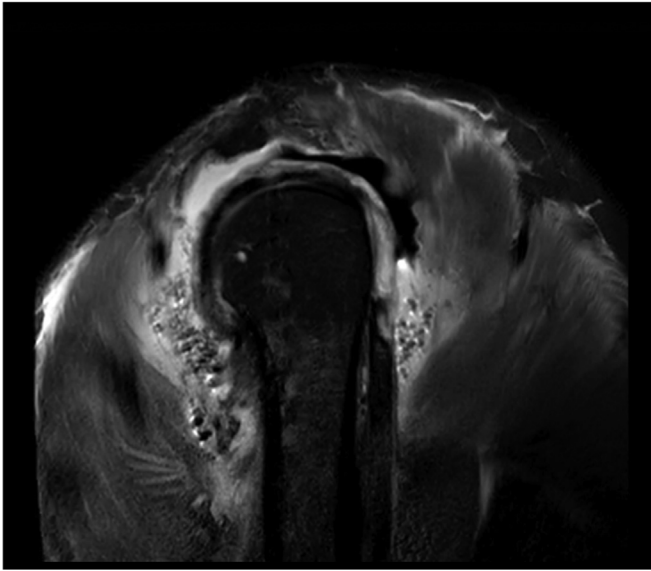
Sagittal oblique fat-suppressed MRI right shoulder. There is extensive subcutaneous edema and gas within the soft tissue, consistent with right shoulder fasciitis.
